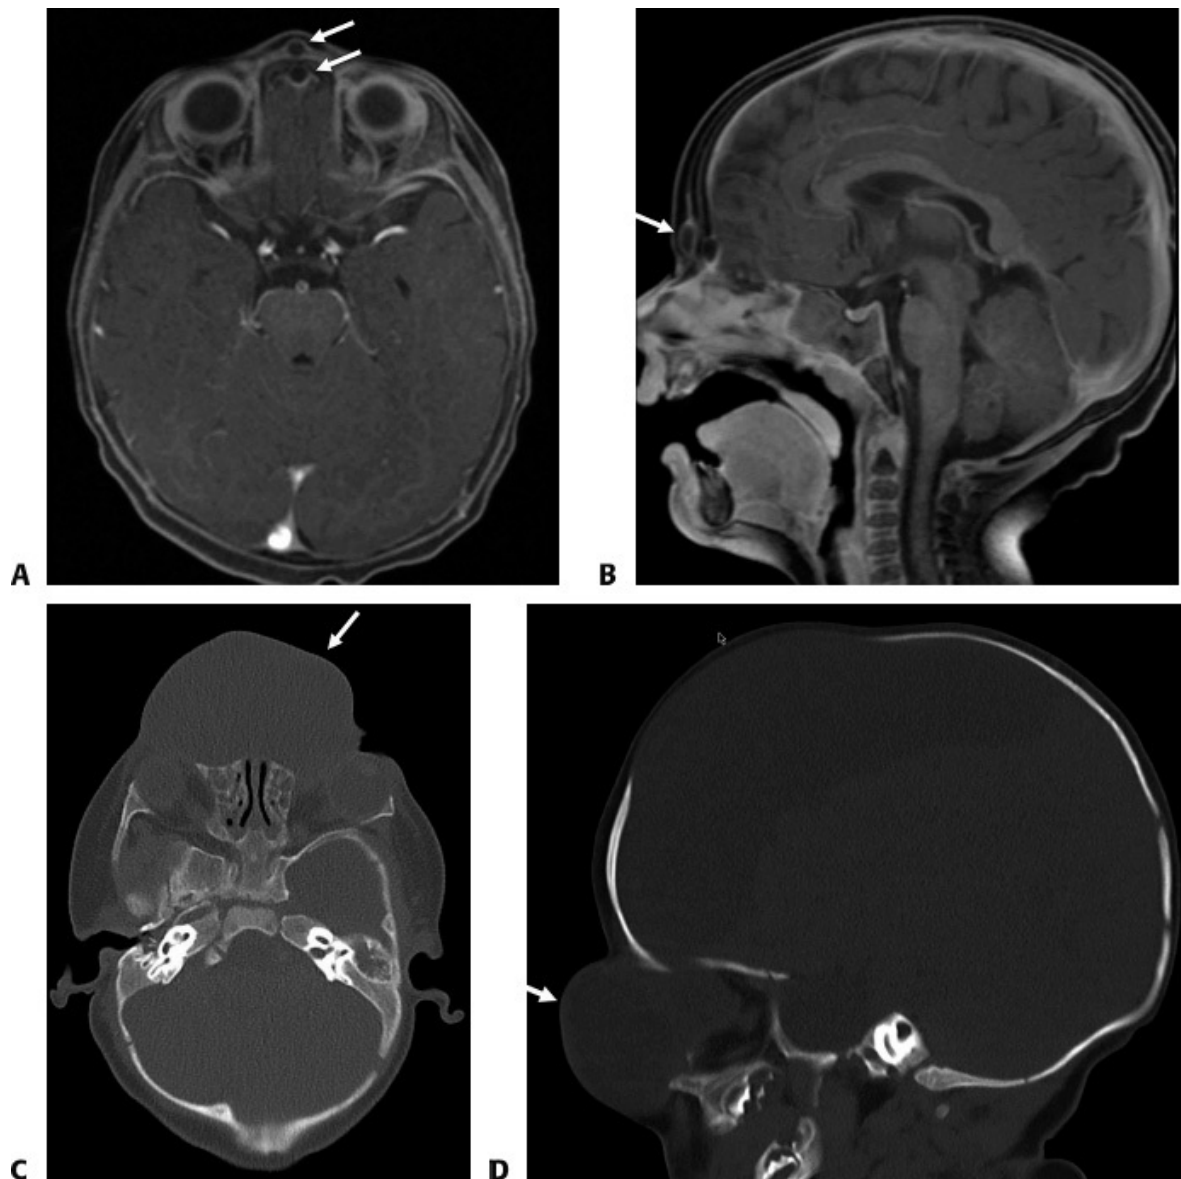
• A,B. MRIs reveal extra and intra components (*arrows*) in a 1-year-old girl with glabellar mass. C,D. Midline encephalocele is apparent in AP and lateral CT scans in a 4-month-old girl.
